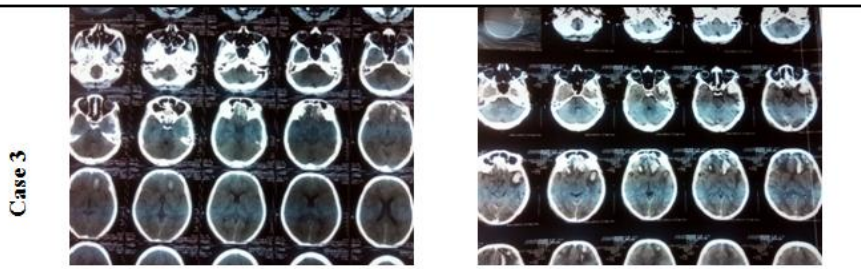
CT scan of head on admission Figure 5b: CT scan of head after 48 hours
